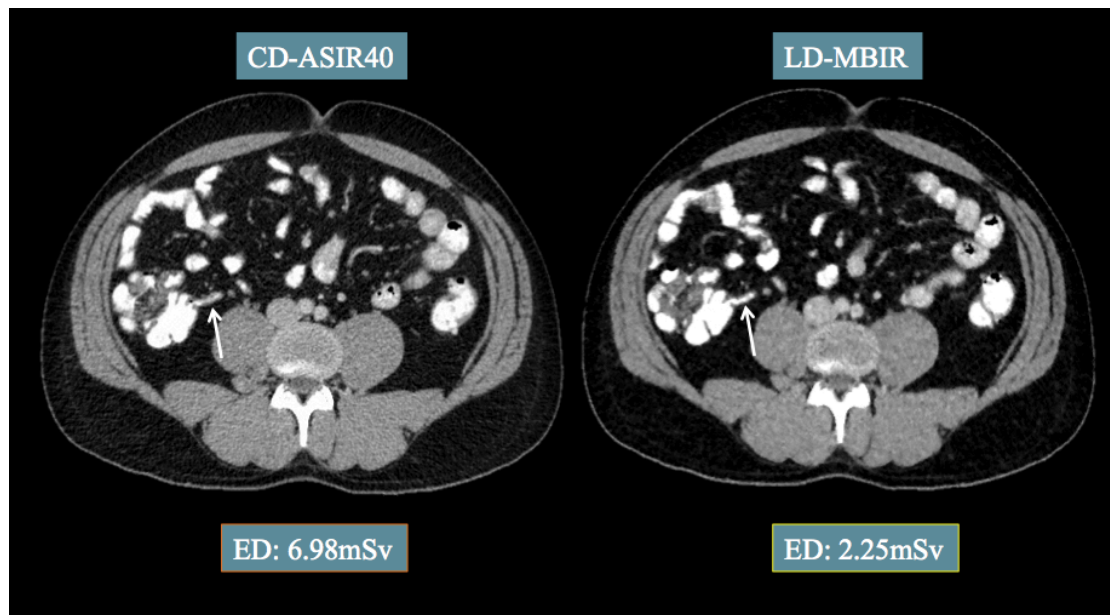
CD ASIR and LD MBIR axial CT images in a 29 year-old male patient presenting with acute abdominal pain with a suspected diagnosis of acute appendicitis. The LD MBIR image acquired at a significantly lower dose than the CD ASIR image show a normal appendix filled with oral contrast.
